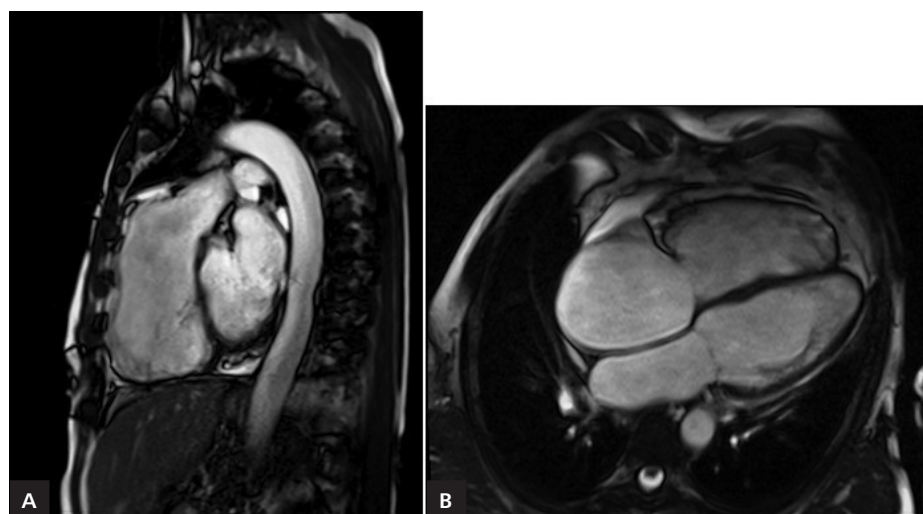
A, B. Cardiac magnetic resonance imaging showed impaired right ventricular systolic function with sacculations, dyskinesia and fibrosis of its free wall. Left ventricular systolic dysfunction plus paradoxical interventricular septum movement
